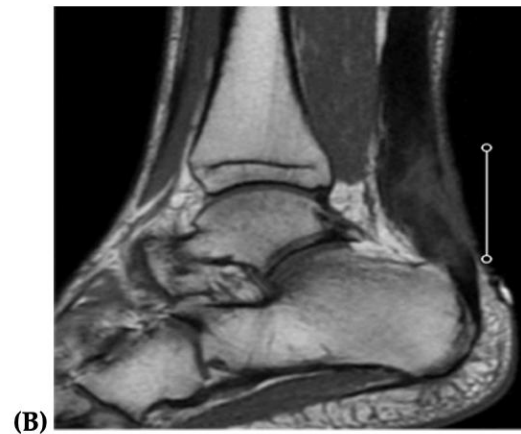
MRI image of a case presented by Haghverdian., et al. Showed a chronic and complete right Achilles tendon rupture with a 2 cm gap. This case is included in Kuwada's classification type II (complete tear < 3 cm defect) and Myerson's classification type I (complete tear 1-2 cm defect).¹⁷
